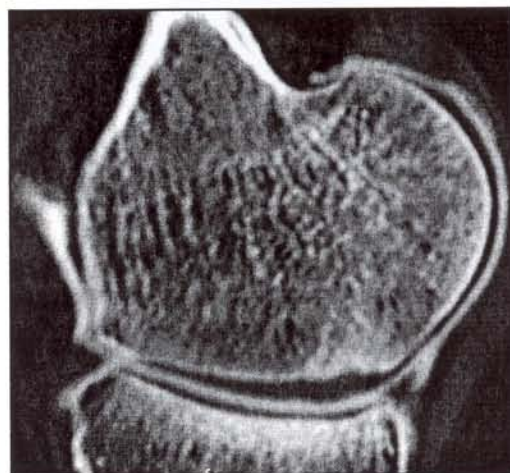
Excellent reconstruction at the medial femur condyl, minimal cartilage thickening and cortical subchondral reaction. MRI 3 years postoperatively.
